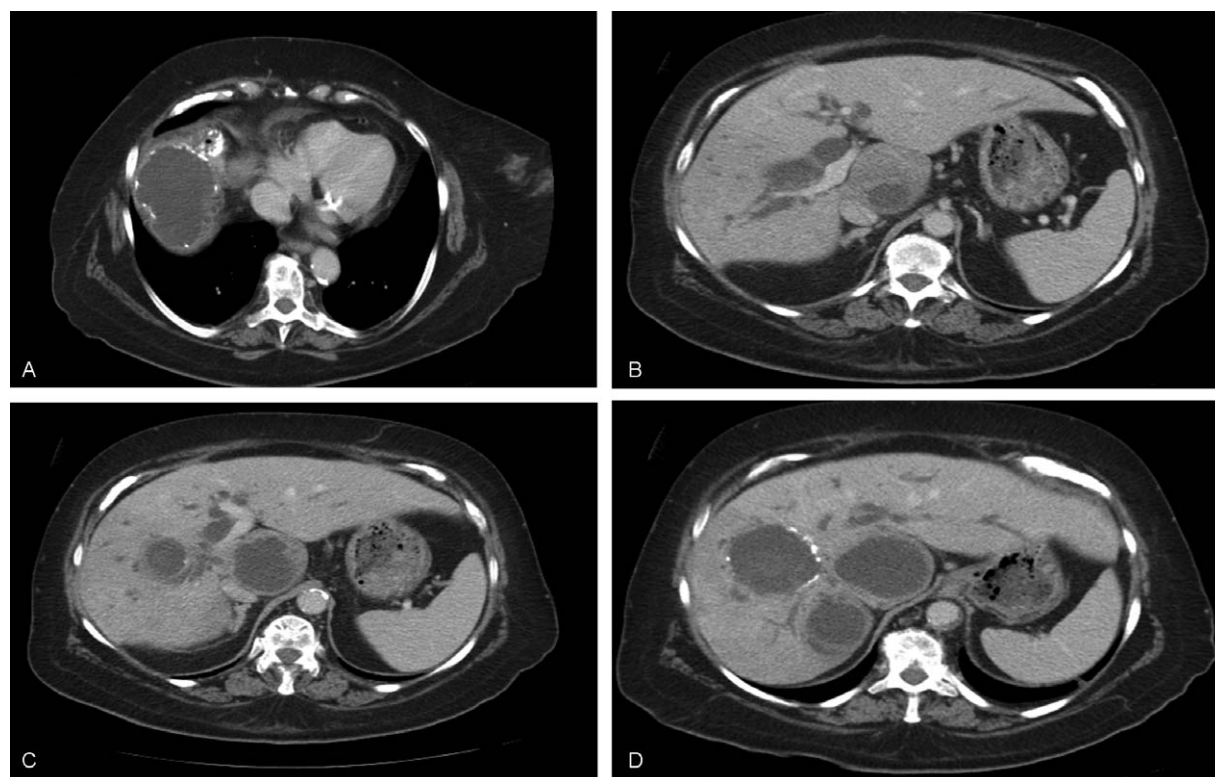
CT scan showing multiple hydatid cysts located in the right lobe of the liver in a 72-year-old man (A–D). There was a cysto-biliary communication with presence of hydatid material in the common bile duct. ERCP plus sphincterotomy was carried out before the surgical operation.
